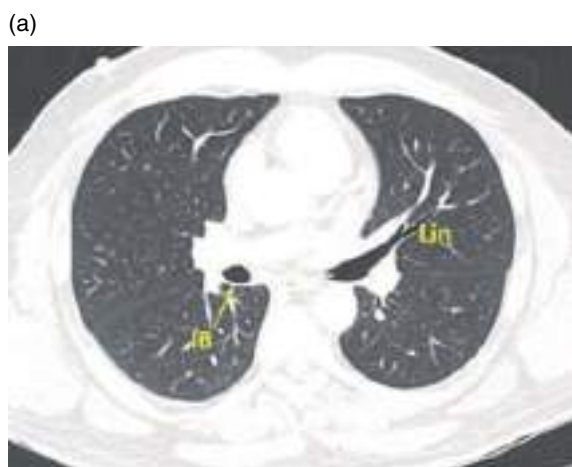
(a) Axial CT image (lung window). IB, intermediate bronchus; Lin, lingular bronchus. (b) Axial CT image (mediastinal window). IPA, interlobar pulmonary artery; SPV, superior pulmonary vein.
